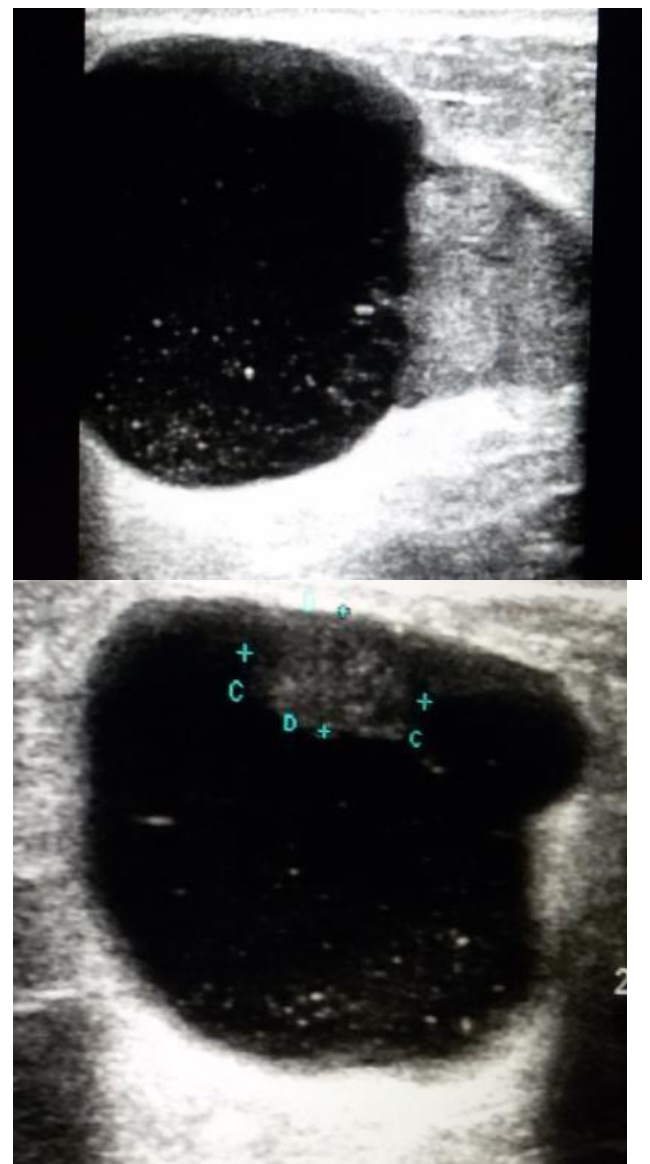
Ultrasonography of left breast. A well defined thick walled cystic lesion measuring with a solid mural component. Diffuse low level echoes representing intracystic tumoral hemorrhage.
